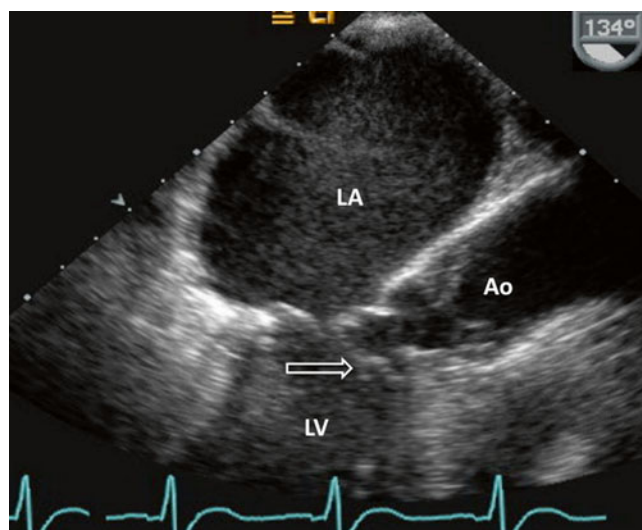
Transesophageal echocardiographic (TEE) image of subvalvular membrane (arrow), favoring septal myectomy. Ao aorta, LA left atrium, LV left ventricle
